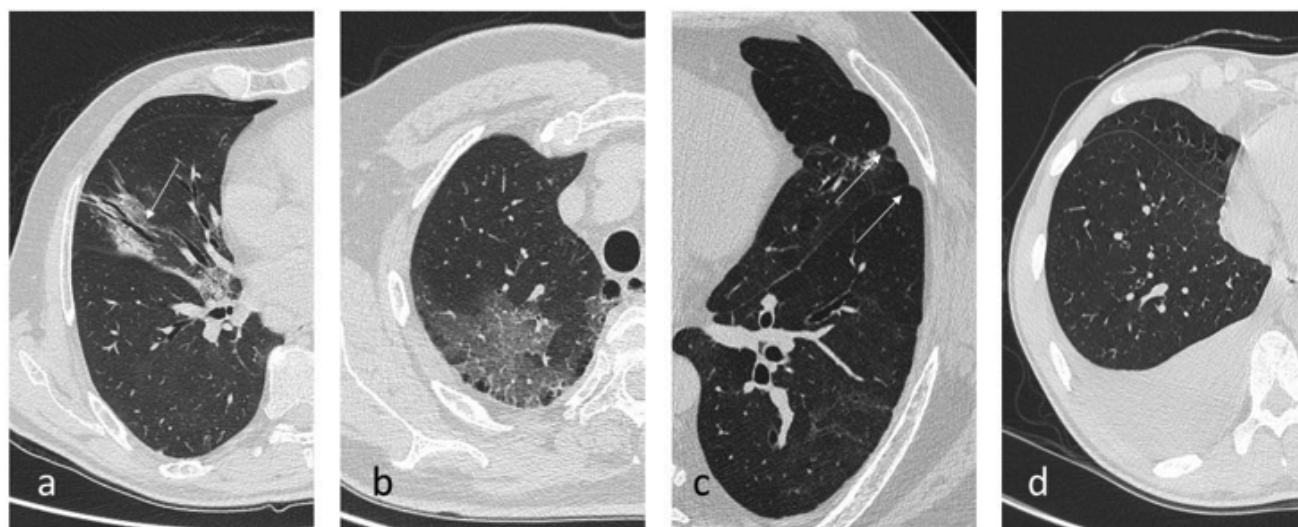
Chest CT findings of COVID-19 pneumonia. a) Traction bronchiectasis. b) Ground-glass opacities. c) Pleural effusion.
